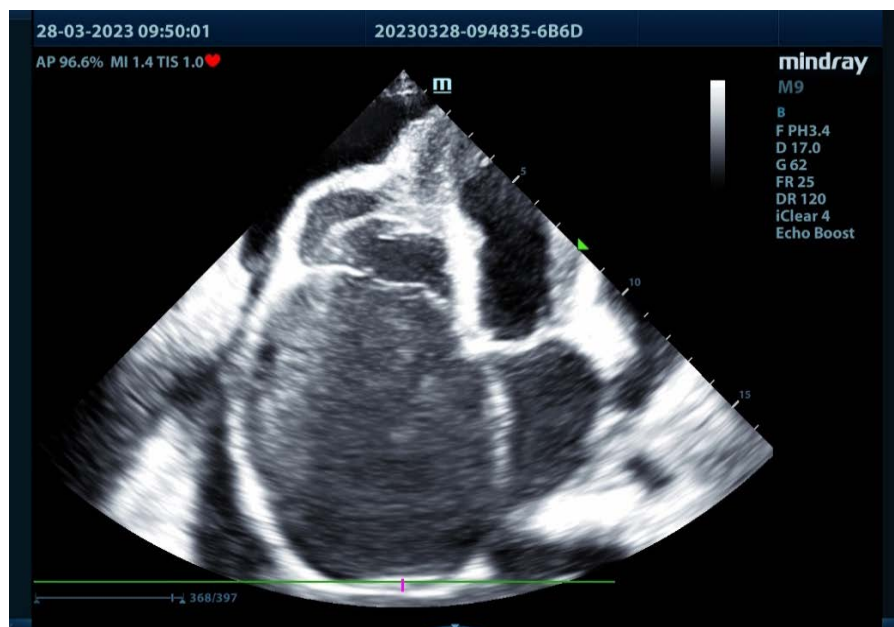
Echocardiography of Ebstein's anomaly.
